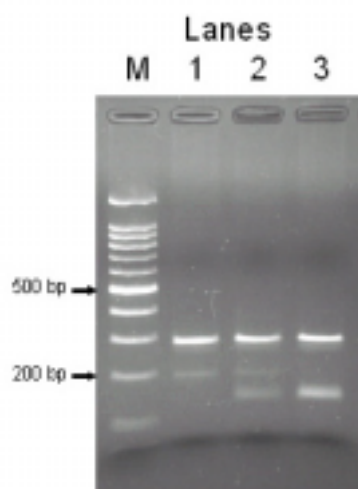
Polymorphism of the CRP C1444T. Lane M is for a 100-bp DNA ladder. Lane 1 for CC genotype (187- and 280-bp bands), lane 2 for CT genotype (137-, 187- and 280-bp bands), and lane 3 for TT genotype (137- and 280-bp bands).
